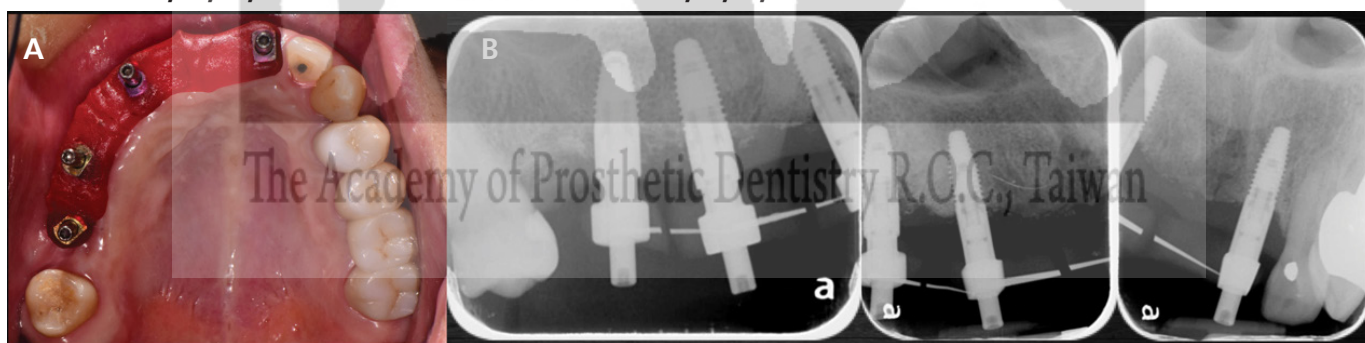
Splinting the 13,15,16,21 impression copings with self-cured resin material. (a) occlusal intraoral view; (b) periapical film
